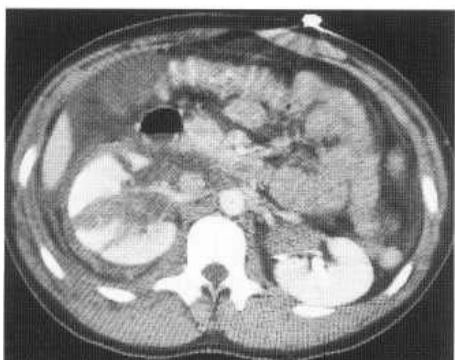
Contrast CT showing a shattered kidney (multiple fractures).
